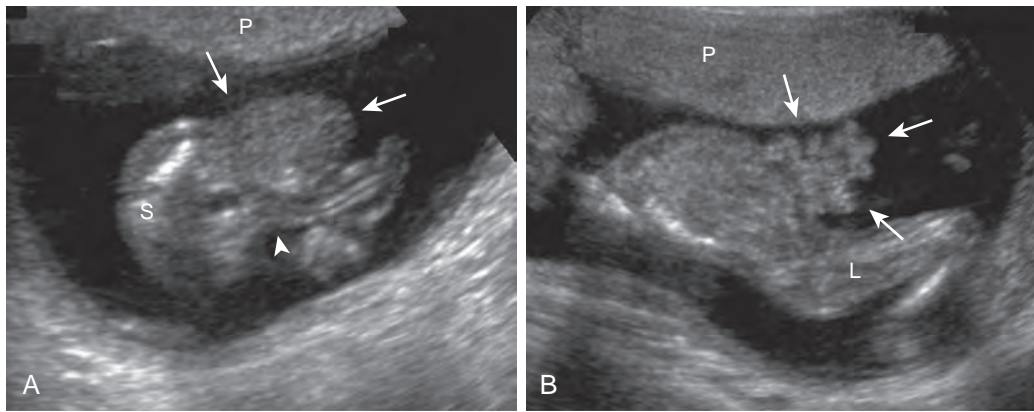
Gastroschisis. A. The prenatal transverse ultrasound image demonstrates the bowel (arrows) herniating through an anterior abdominal wall defect to the right of the umbilical cord insertion (arrowhead). B. The sagittal image demonstrates eviscerated bowel floating loosely in amniotic fluid without a membranous covering (arrows). L, Lower extremity; P, placenta; S, spine.
